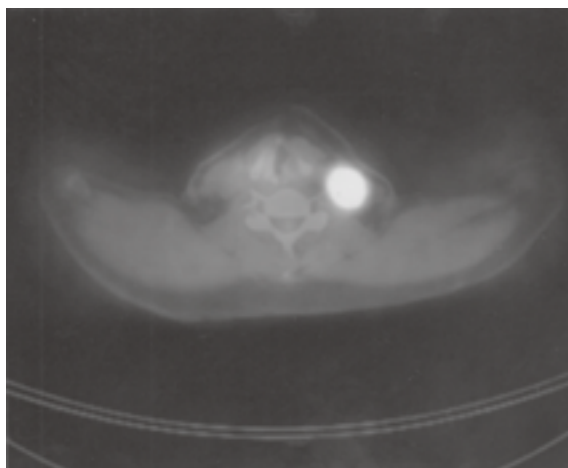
PET/CT fusion image of the same lesion in Fig. 1a.
